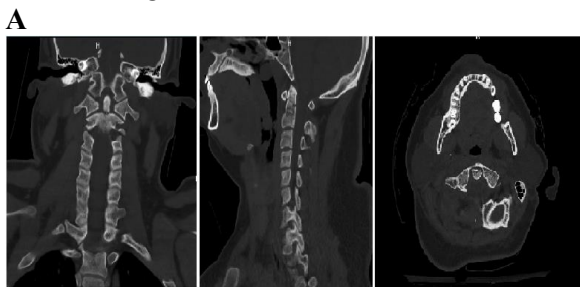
Cervical CT scan (coronal, sagittal and axial view)
